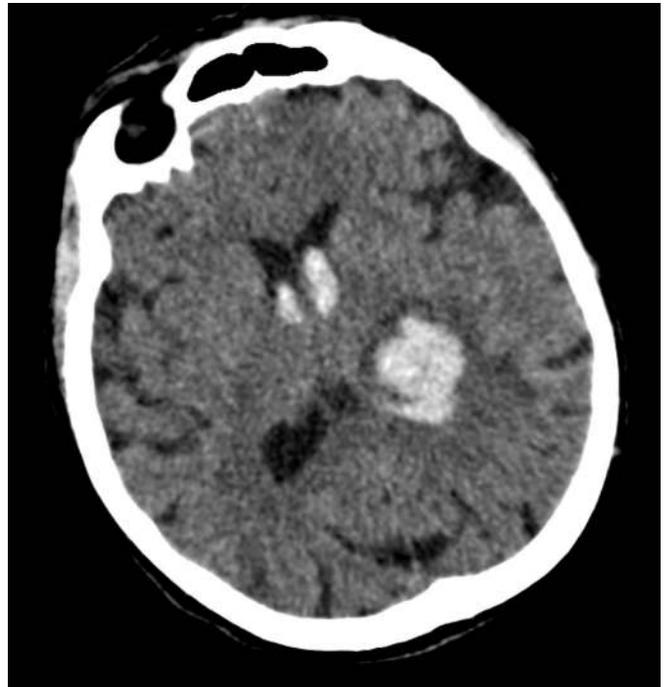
CT Scan Showing Associated Intraventricular Hemorrhage in the Setting of Acute Thalamic Intracranial Hemorrhage.
